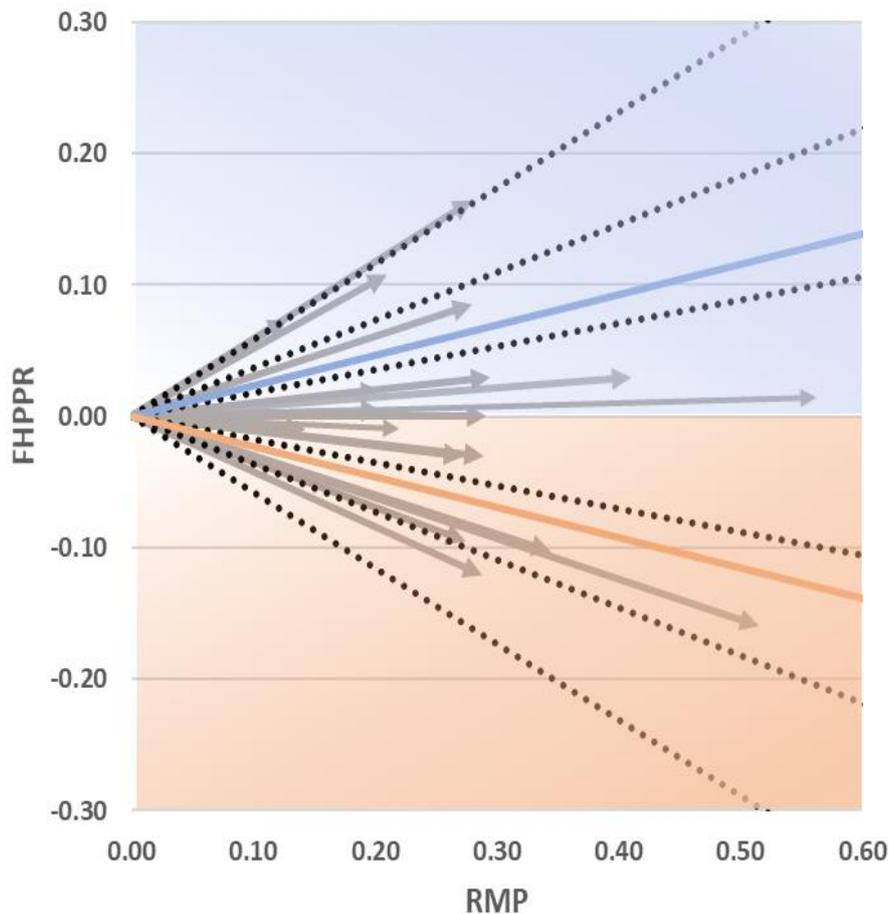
Hip displacement direction and magnitude for each of the individuals in the study. The vertical axis is the anterior-posterior direction, with the blue zone indicating posterior displacement and the blue line representing 13° posterior displacement. The orange zone indicates anterior displacement and the orange line represents 13° anterior displacement. The hashed lines represent +/- 10°, 20° and 30° deviation from true lateral. The horizontal axis is the medial-lateral direction. The greater the magnitude of the arrow the more displaced the greater the hip displacement. RMP (from X-ray) and FHPPR (from 3D ultrasound) are assumed to be orthogonal for this analysis.
